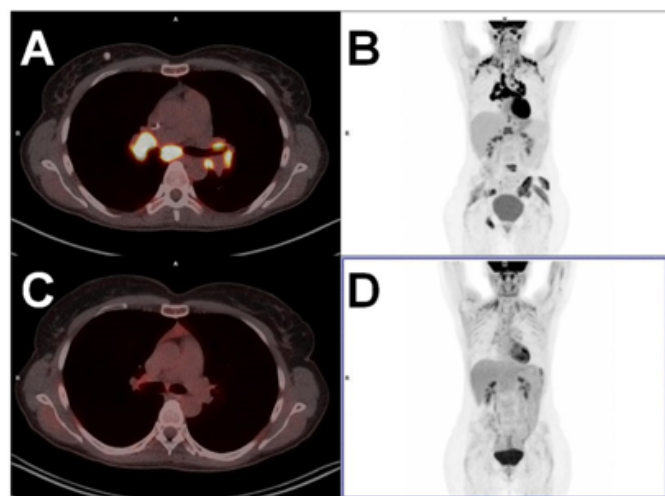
After SCT monitoring: ¹⁸F-FDG PET/CT performed on day +100 after SCT (1A, 1B, 2A, 2B) compared with PET-CT 12 months after SCT (1C, 1D, 2C, 2D). Nodal and osseous FDG uptake were highly suggestive of malignancy; however, a mediastinoscopy confirmed NNGL diagnosis
